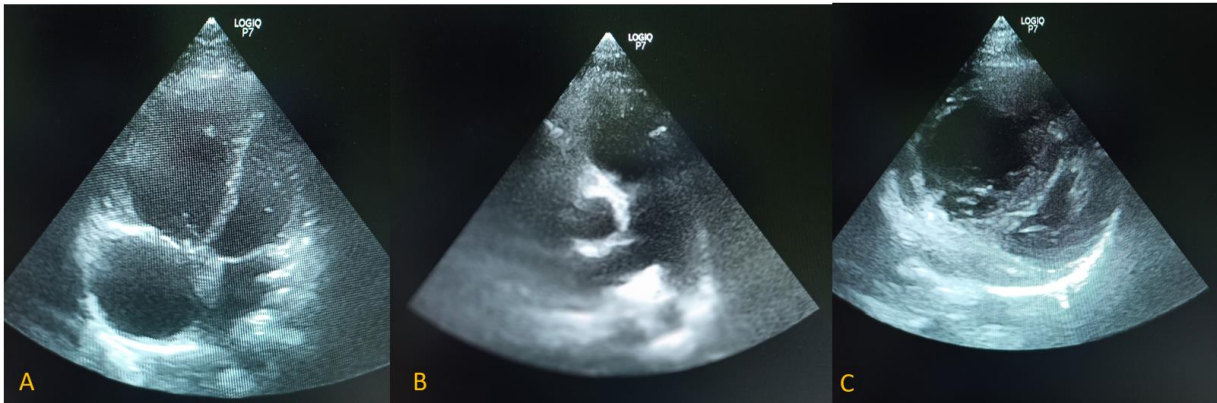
Echocardiography examination showed RV and RA dilatation, intact interventricular septum and intact interatrial septum (figure 3a), dilataion of pulmonary artery diameter (figure 3b) and RV dominant with RV/LV basal diameter ratio =2,5.
